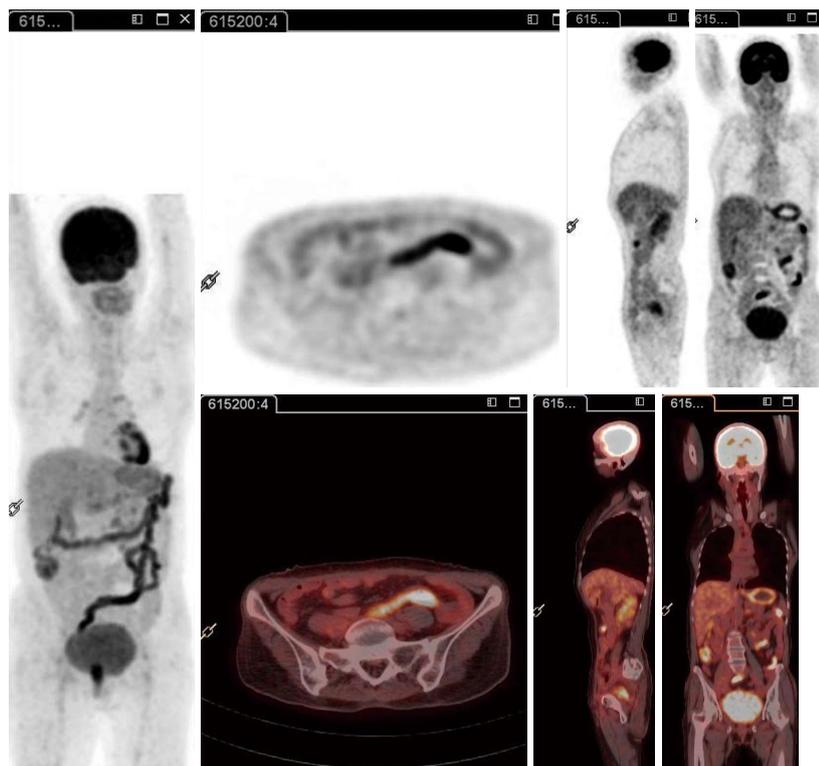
Follow-up fluorodeoxyglucose-positron emission tomography/computed tomography following administration of 3 cycles of systemic chemotherapy and local external radiotherapy demonstrating near-complete resolution of the fluorodeoxyglucose uptake in the psoas muscle as well as other foci.
